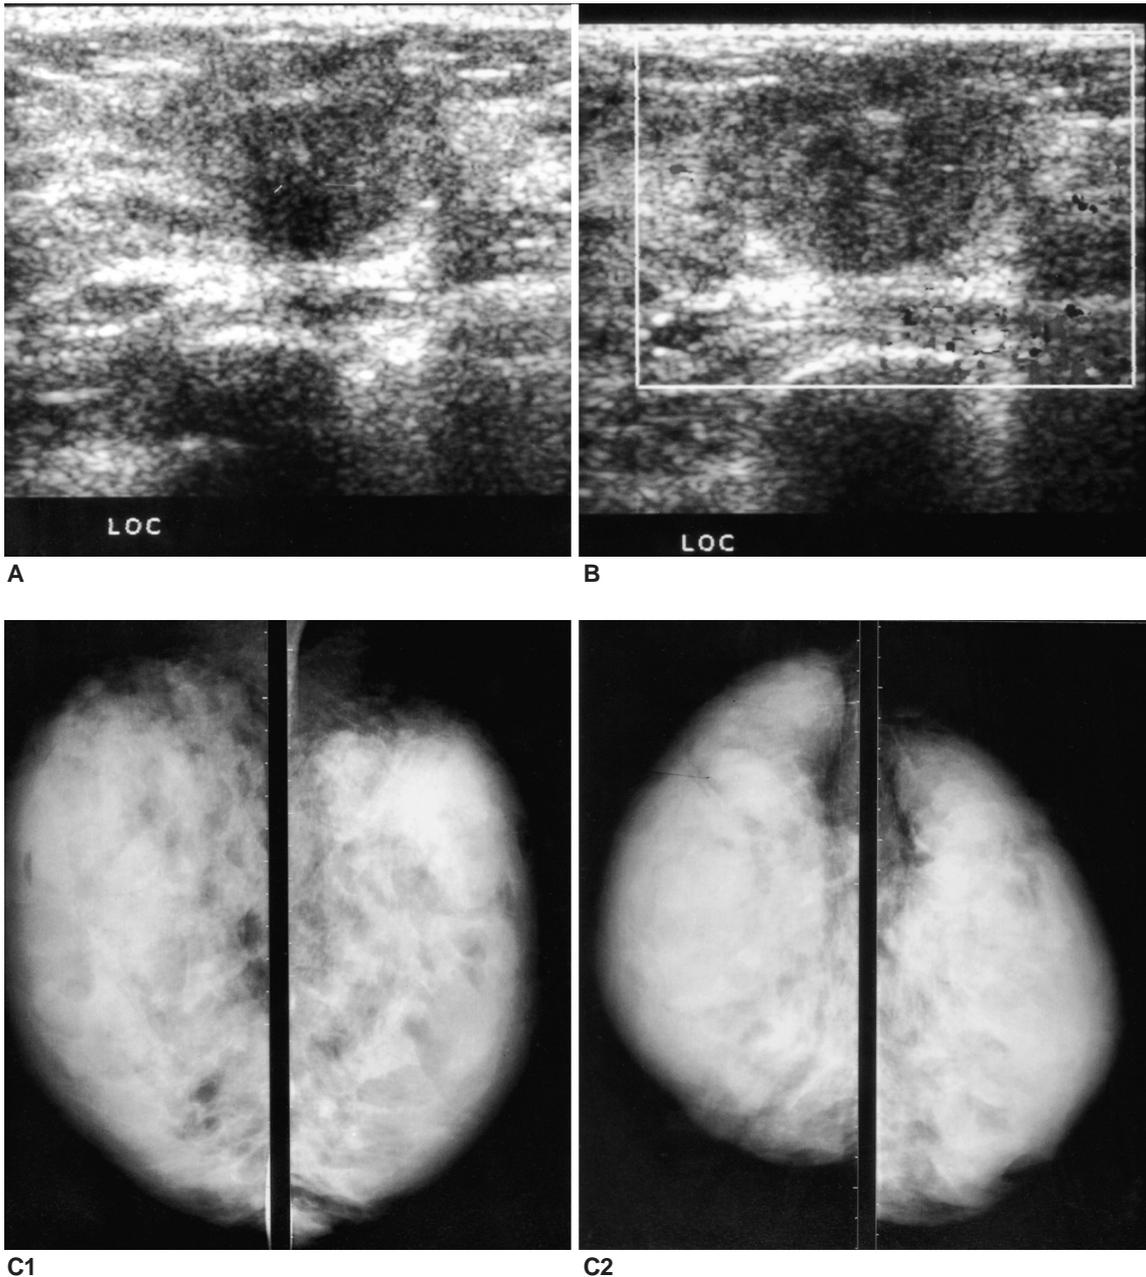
A 31-year-old woman with IUP 21 weeks presented with a palpable lump in the left breast. A. Sonography showed an ill-defined low echoic mass with non-parallel orientation. B. On Doppler US study, increased blood flow was noted in central portion of the mass. C. Bilateral mammograms showed extremely dense breasts without mass or calcifications in the both breasts (BI-RADS Category 1).
